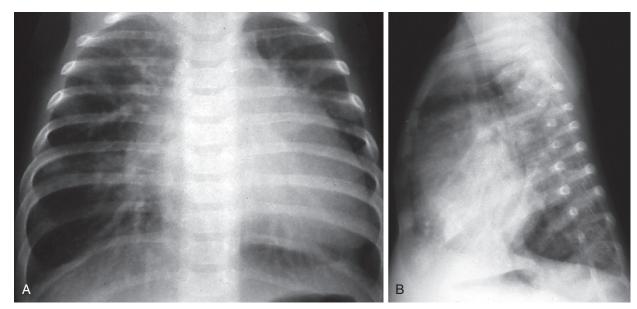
Large left-to-right shunt from a ventricular septal defect. Posteroanterior (A) and lateral (B) radiographs from a 2-month-old infant. Note the increased pulmonary vascular markings and lung hyperinflation. The flattened hemidiaphragms are clearly seen on the lateral projection, a finding predictive of associated pulmonary hypertension.
